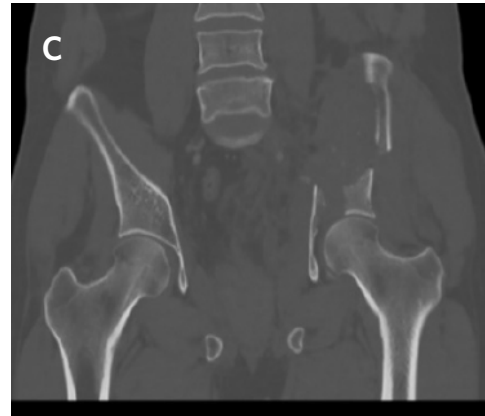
Bone CT of Pelvic Fracture. Published with Permission
